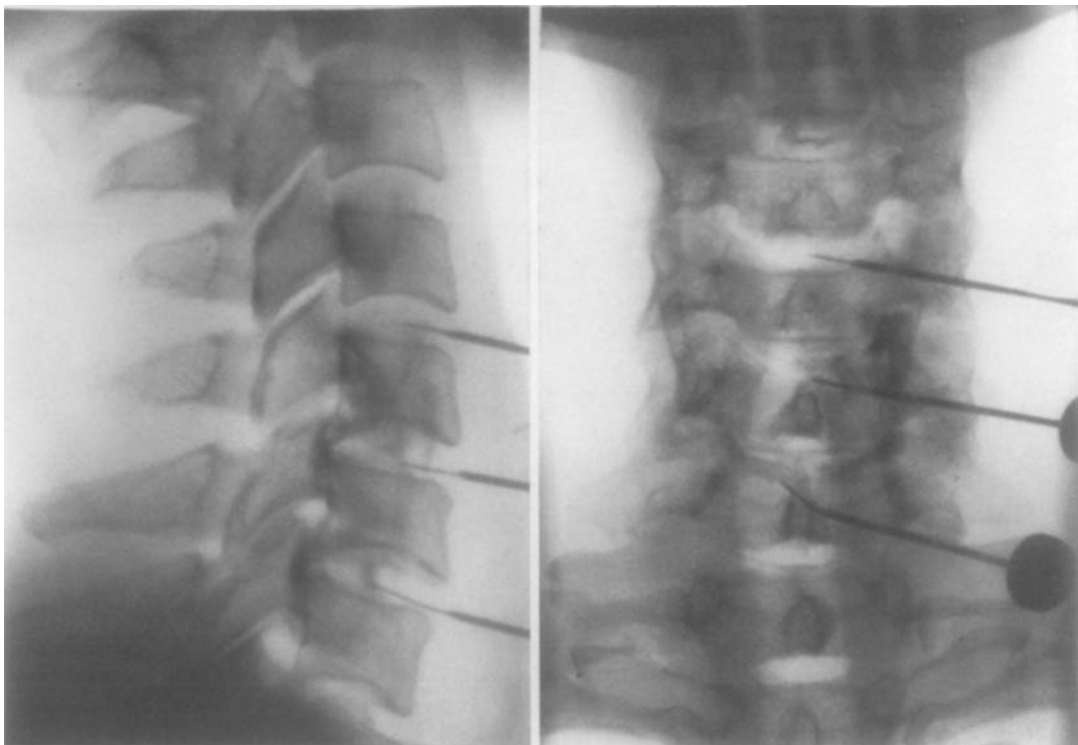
B Female patient of 48. On plain films the C.V—C.VII levels look normal. Needles have been introduced under television X-ray control in order to perform discograms at C.V, C.VI and C.VII disc levels. Water soluble radio-paque contrast has been injected into C.VI and C.VII but not yet into C.V. The contrast has leaked mainly postero-laterally bulging into the spinal canal and the intervertebral foramen through the uncus region.
